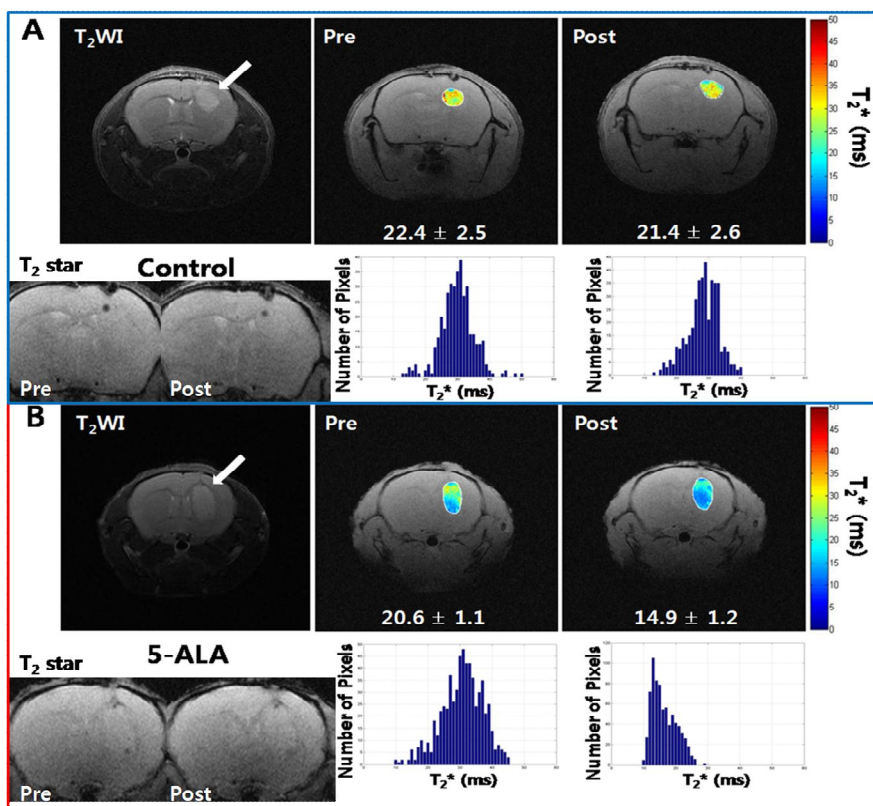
MRI detection of heme synthesized as a result of PpIX generated by 5-ALA treatment in U-87 glioblastomas. (A, B) The number of pixels (blue bars) was used to calculate the mean T_2^* value, and these values were used for the detection of heme-induced changes in T_2^* . The mean
